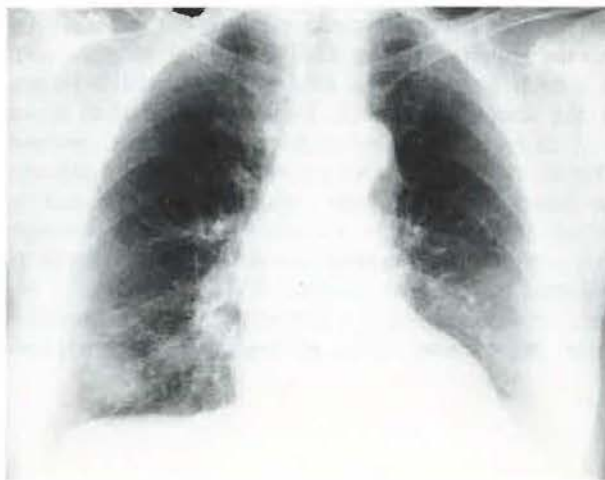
Chest roentgenogram, March 1982, a few days before the first hospitalization.
